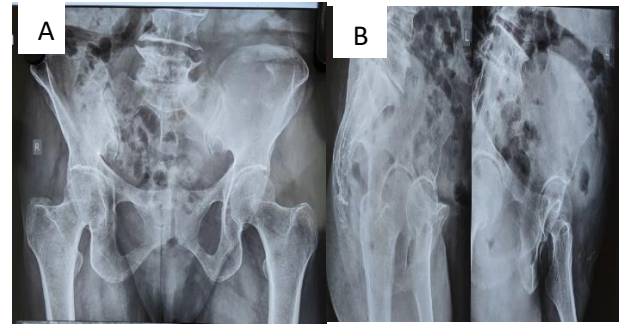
A) and B) showing X-ray of pelvis and hip joint with no bony lesions.
